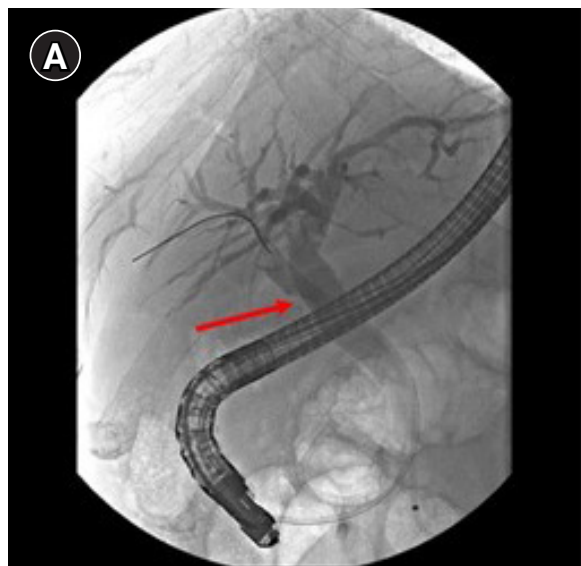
A focal filling defect with a smooth margin at the right posterior hepatic duct (arrow). (A) Endoscopic retrograde cholangiopancreatography and (B) endoscopic ultrasonography.
